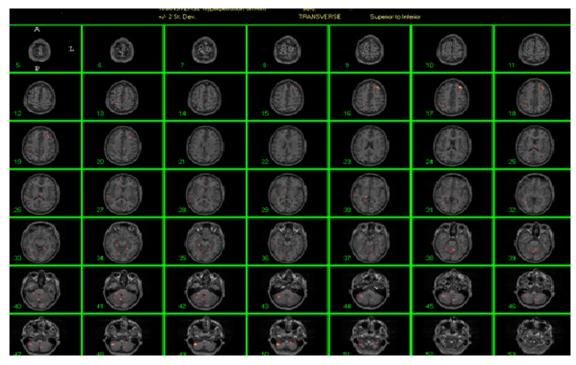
SISCOM analysis demonstrating a focus of ictal activity registering to the left frontal lobe anteriorly. SISCOM, subtraction ictal single-photon emission computed tomography co-registered to MRI. (Color version of figure is available online.)
